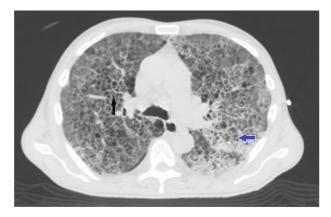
Computed tomography at the time of ICU evaluation; there is new onset of interstitial opacity and ground glass opacity (blue arrow) and interlobular thickening (black arrow).
